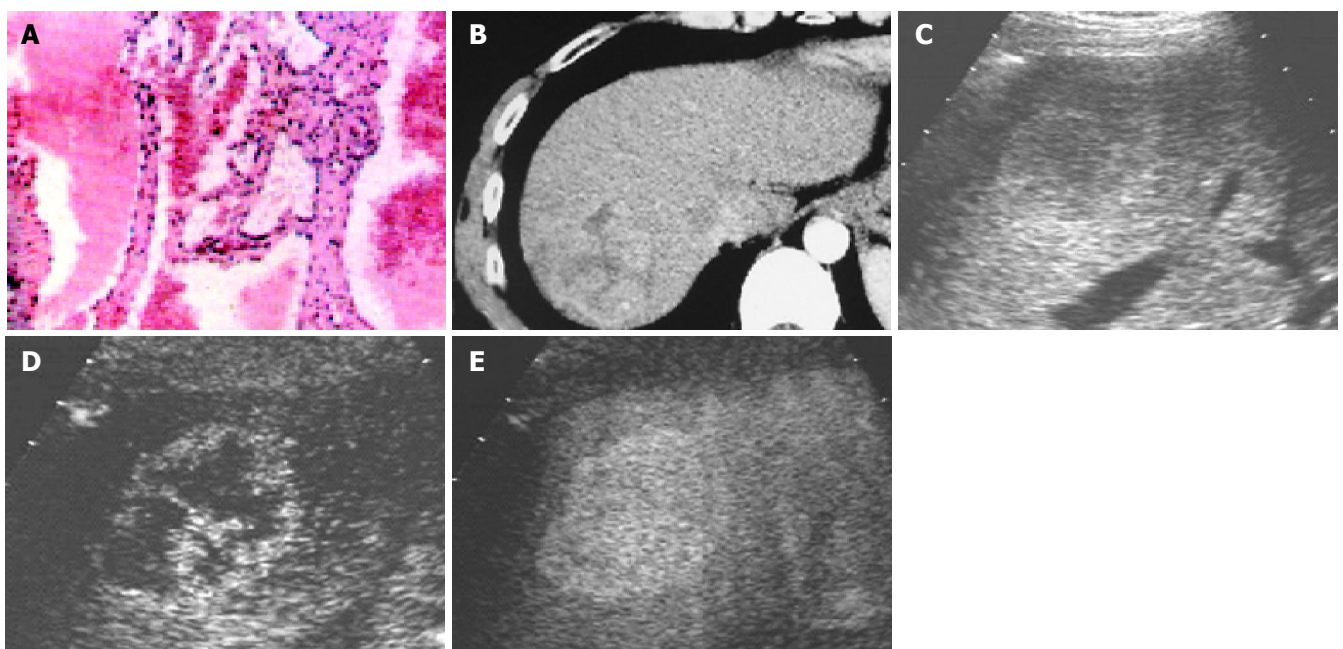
A: a 4.1 cm-sized hemangioma; B: heterogenous high attenuation on contrast-enhanced CT; C: hypoechoic lesion on B-mode image; D: the spot-like
